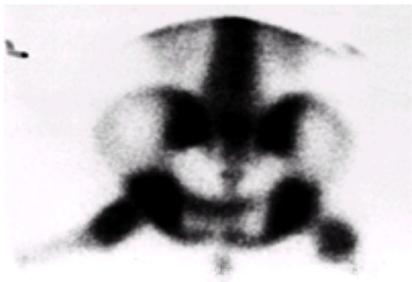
The scintigraphic appearance of a technetium 99m bone scan of a hip with idiopathic chondrolysis demonstrates a diffuse increased uptake of the isotope by both sides of the affected hip.
